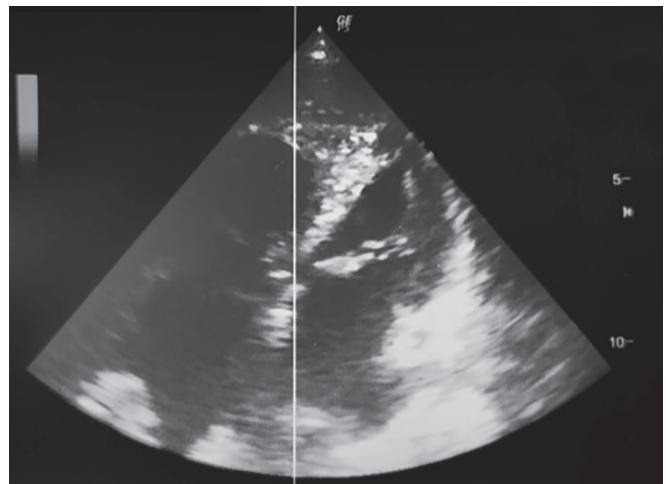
Echocardiography image showing dilatation of RA and RV with ostium secundum ASD
